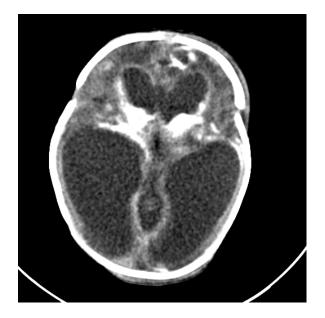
1-day-old male has scalp swelling and a weak cry. Extensive periventricular, basal ganglionic and parenchymal calcification with hydrocephalic changes and parenchymal atrophy can be seen on the computed tomography scan.
